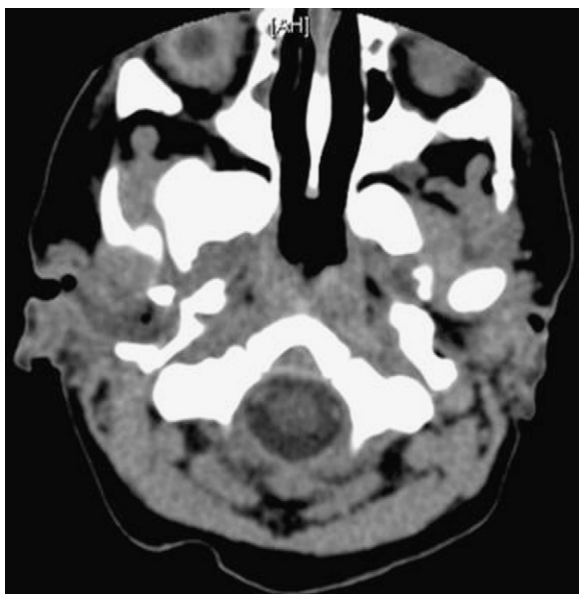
Axial CT showing almost complete opacification of the right EAC.
